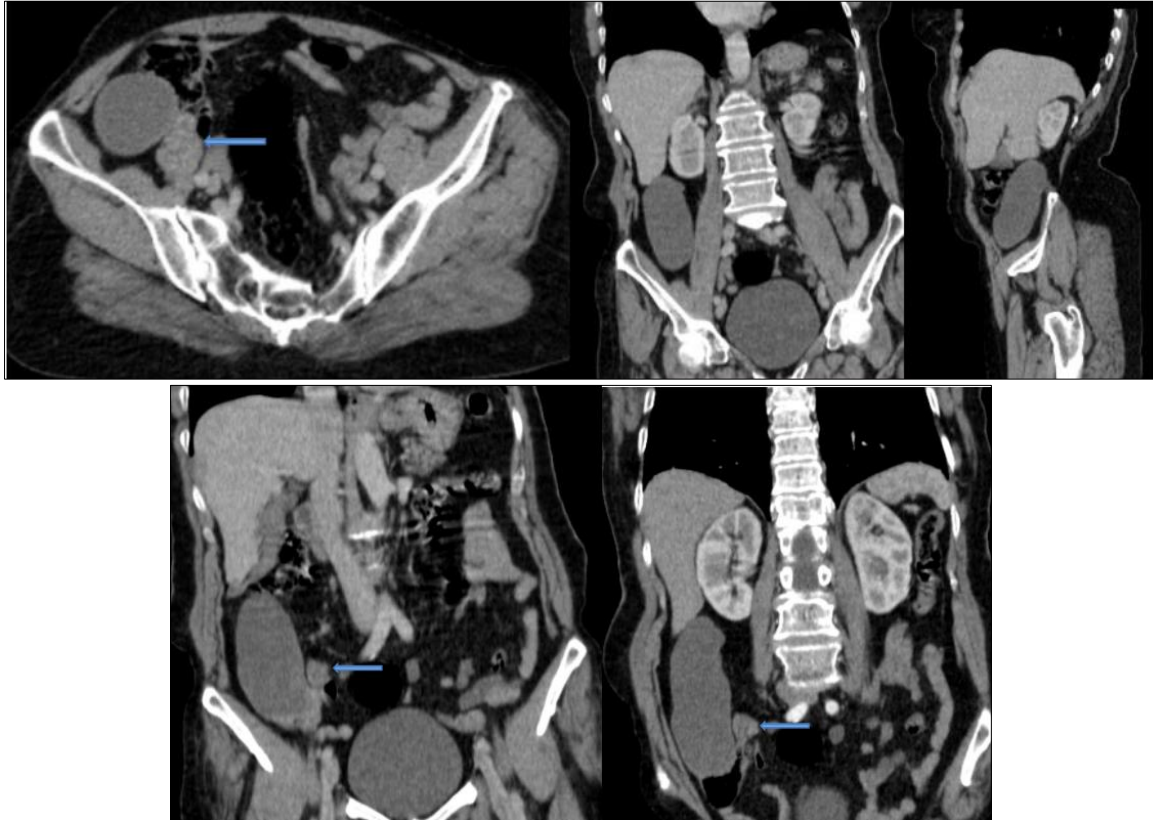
Axial, coronal, and sagittal CT images showing an oblong formation involving both ends of the appendix (blue arrow). The lesion shows no enhancement after contrast injection and demonstrates neither mural thickening nor wall enhancement
